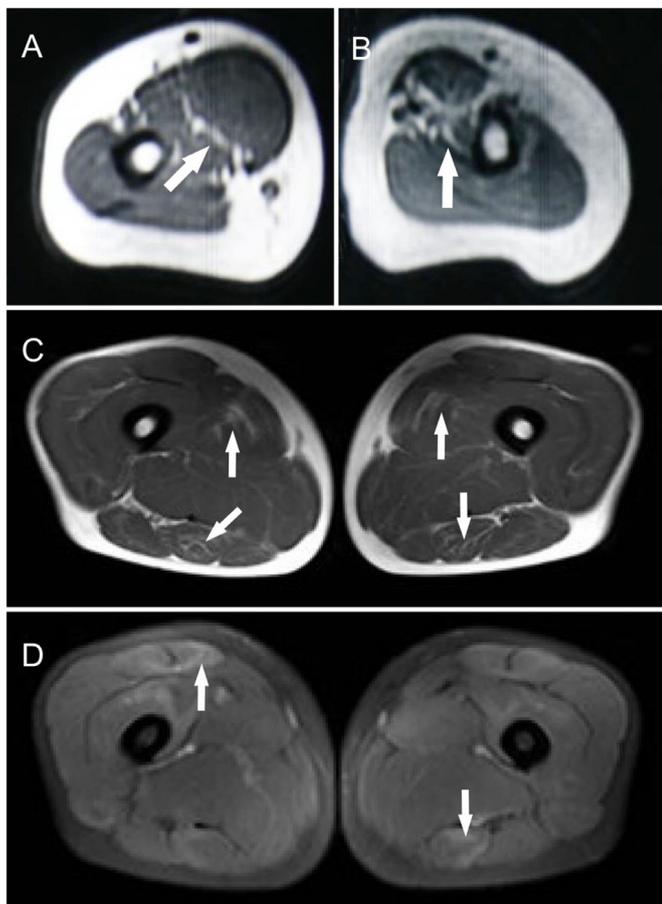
MRI changes in AMA-associated IIMs. (A and B) T1-weighted images showed asymmetrical fatty infiltration and atrophy in the arms in Patient 4 (white arrows). (C) T1-weighted images showed focally fatty infiltration in the muscles of the thigh in Patient 7 (white arrows). (D) A STIR image revealed mild focal edema in the muscles of the thigh in Patient 7 (white arrows). Abbreviations: MRI, magnetic resonance imaging; AMA, anti-mitochondrial antibody; IIM, idiopathic inflammatory myopathy; STIR, short-tau inversion recovery.
